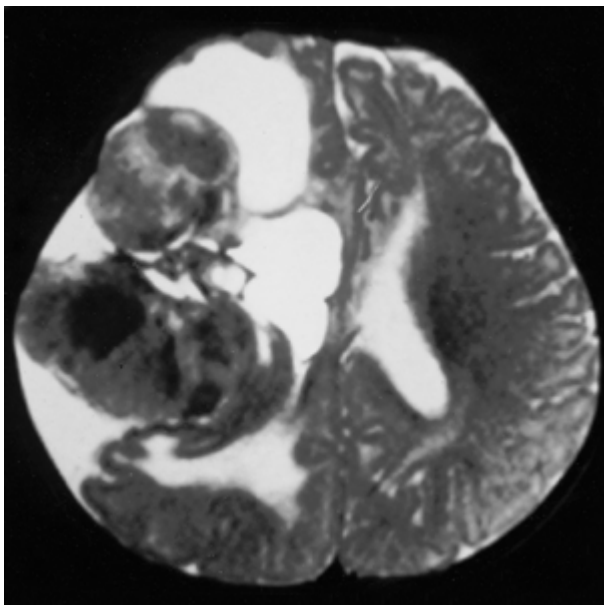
MR T2-weighted image of brain demonstrated a heterogeneous signal in solid and cystic mass.
